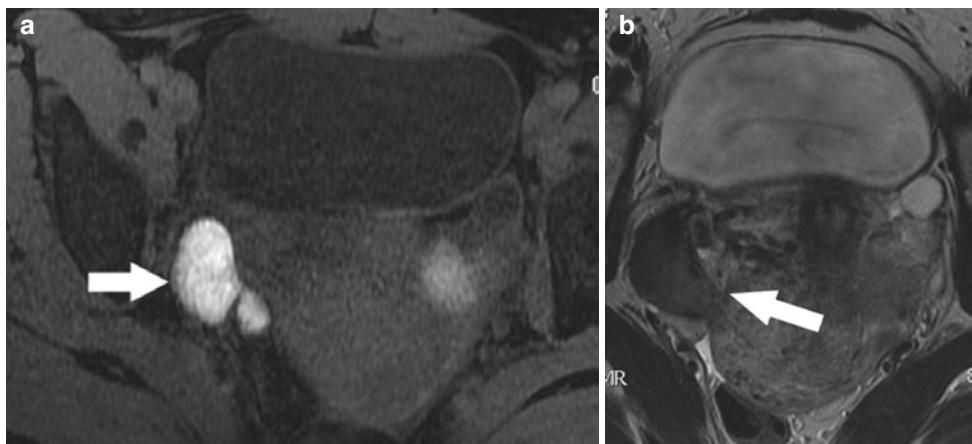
27 year old woman with chronic pelvic pain. (a) Axial fat-saturated T1-weighted MR image shows a high signal intensity structure in the right adnexa (white arrow)
